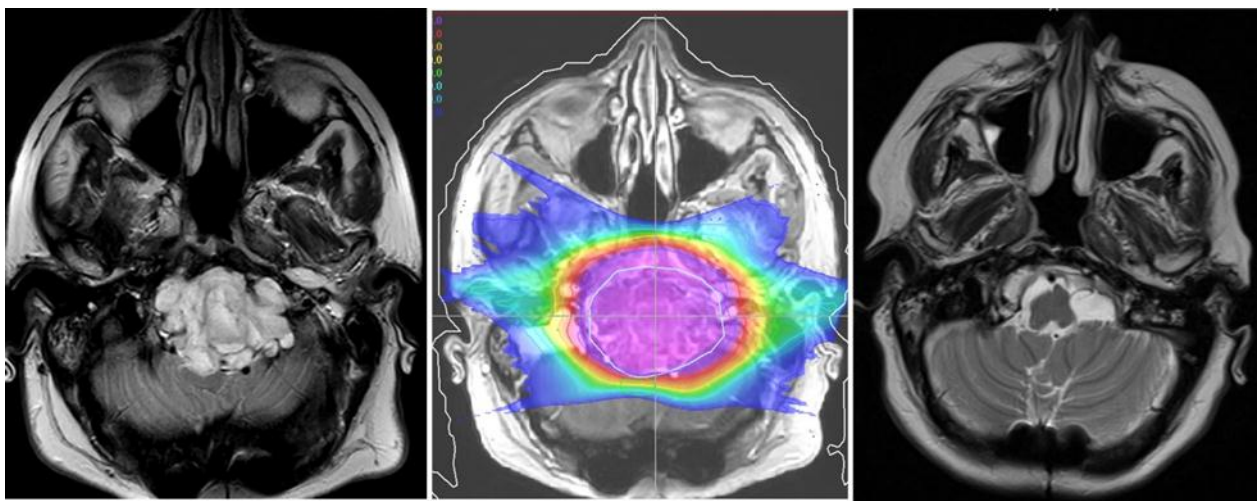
Example of proton finely divided therapy for skull base chordoma: MRI before treatment (left), irradiation plan (in the middle) and MRI 2 years after - significant tumor regression
